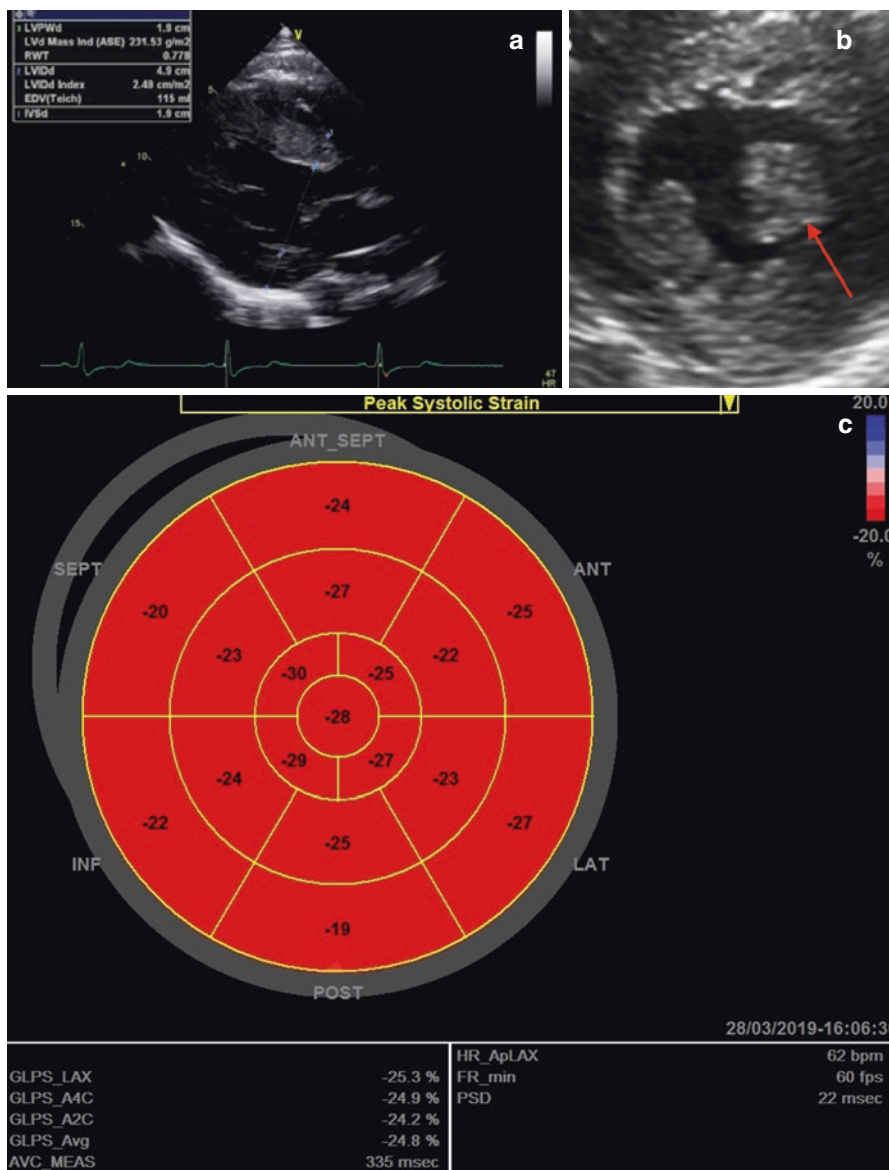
(a) Transthoracic echocardiogram showing typical left ventricular hypertrophy, seen on parasternal long axis view. (b) Prominent papillary muscles (arrow) seen on short axis view. C: “Bullseye” plot showing LV longitudinal strain in a healthy control. D: Typical distribution of LV peak systolic strain, with impairment primarily in inferoposterior segments (arrow)
